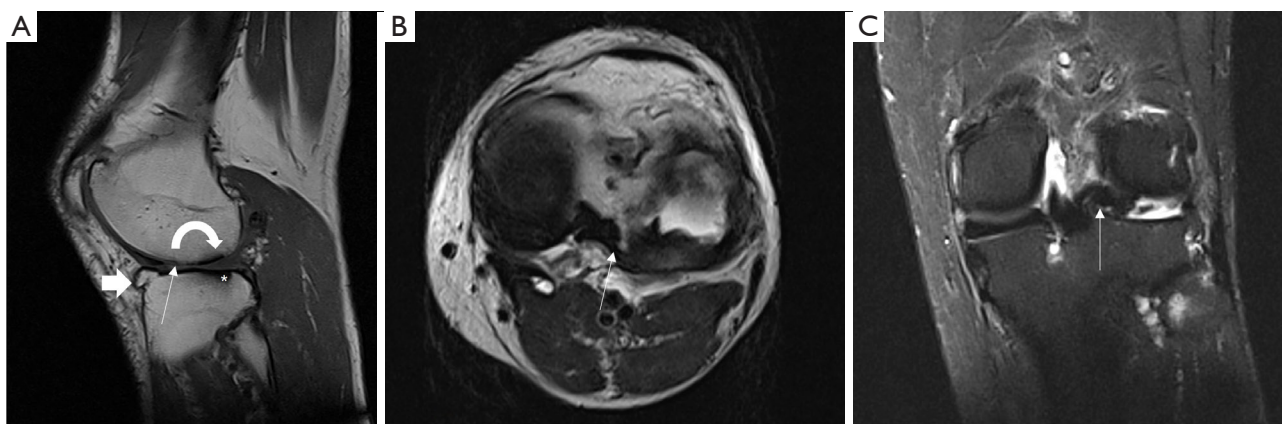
Magnetic resonance images showing advanced degenerative abnormalities. (A) Sagittal T1-weighted image shows loss of the integrity of the external cartilage (straight arrow), subarticular bone abnormalities (asterisk), subarticular abrasion (curved arrow), marginal osteophytes (thick arrow). (B) Axial T2-weighted image shows flap tear of the lateral meniscus posterior horn (arrow). (C) Coronal PD FS sequence shows the meniscal flap in the intercondylar notch (straight arrow) and bone marrow lesion adjacent to ACL distal insertion. PD, proton density; FS, fat saturation; ACL, anterior cruciate ligament.
